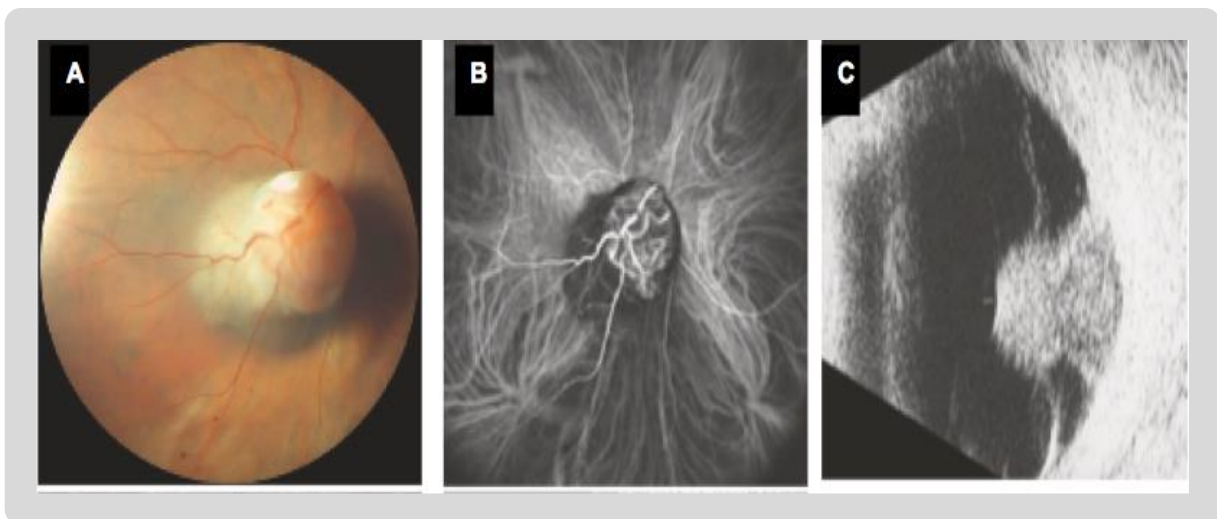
Mushroom-shaped choroidal melanoma with a vascular congestion at its apex and covering the optic disc. (a) Fundoscopy view. (b) ICG angiography. (c) 10 MHz ultrasonography (image sourced from Singh, 2019)[127].
